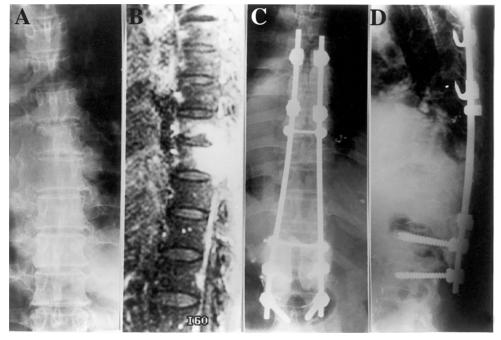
62 years old female presented with breast cancer. (A) Pre-operative anteroposterior radiograph showing pedicle destruction at T7 and T8; (B) Sagittal magnetic resonance scan showing pathological fractures of the T7 and T8 and an abnormal marrow signal extending into the posterior element; (C-D) Postoperative radiographs showing stabilization with Moss-Miami hook and pedicle screws with bone cement.
